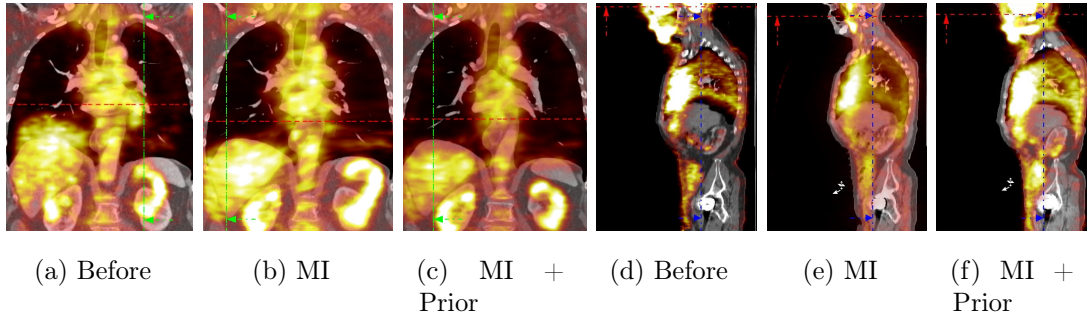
Fused views of attenuation corrected (AC) and non-AC PET/CT data registered using mutual information (MI) and our proposed integrated SIP model. Adding prior knowledge increases registration quality where purely data-driven registration fails.
